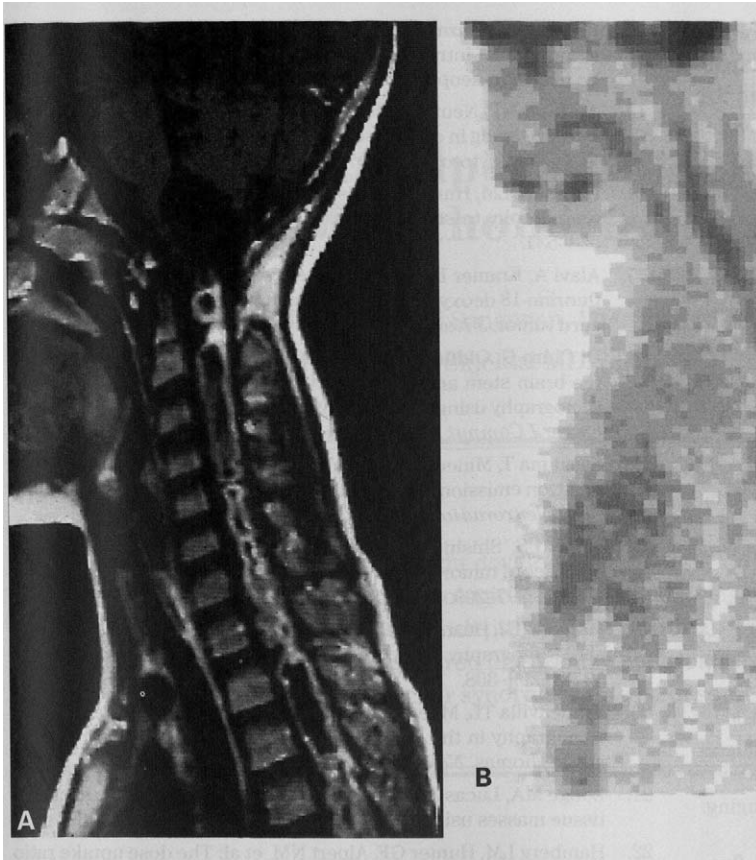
Case 2. A, Sagittal cut of T₁-weighted MRI with gadolinium (TR 450; TE 25). Postoperative appearances of a grade 2 ependymoma with significant tumor remaining extending from C1 to T6. B, PET imaging (sagittal cut) confirming increased FDG uptake from the brain stem to the conus with some additional postsurgical changes.
